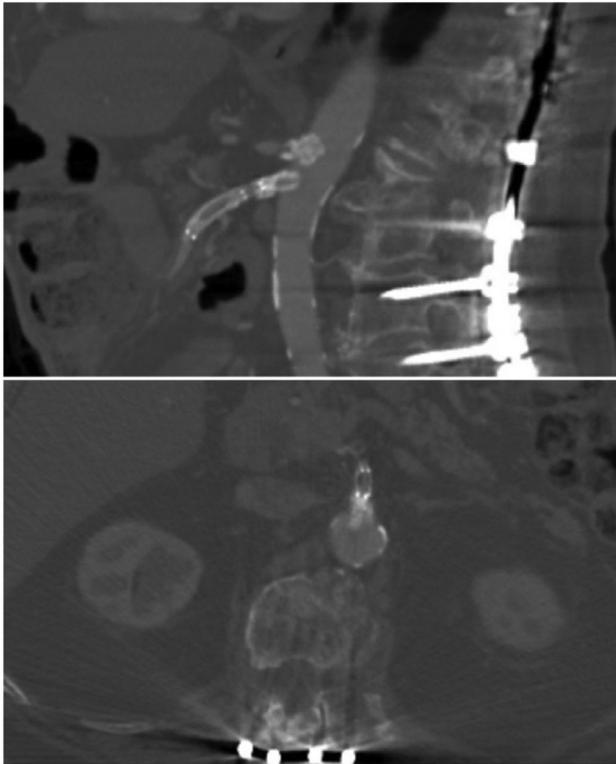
Representative sagittal and axial CT cuts of a 69 year old man who sustained an acute superior mesenteric artery thrombosis following adult spinal deformity correction with 3-column osteotomy. The SMA is visualized here following stenting. The lumen of the duodenum is seen anterior to the aorta and inferior to the SMA on the sagittal view. This patient sustained an ischemic bowel injury, ultimately requiring partial bowel excision.
